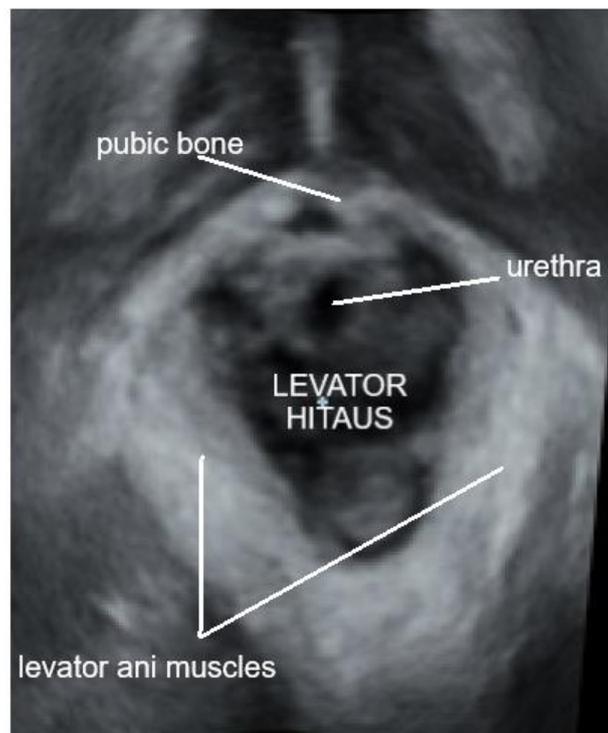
Ultrasound reconstruction of the levator hiatus (personal data)
